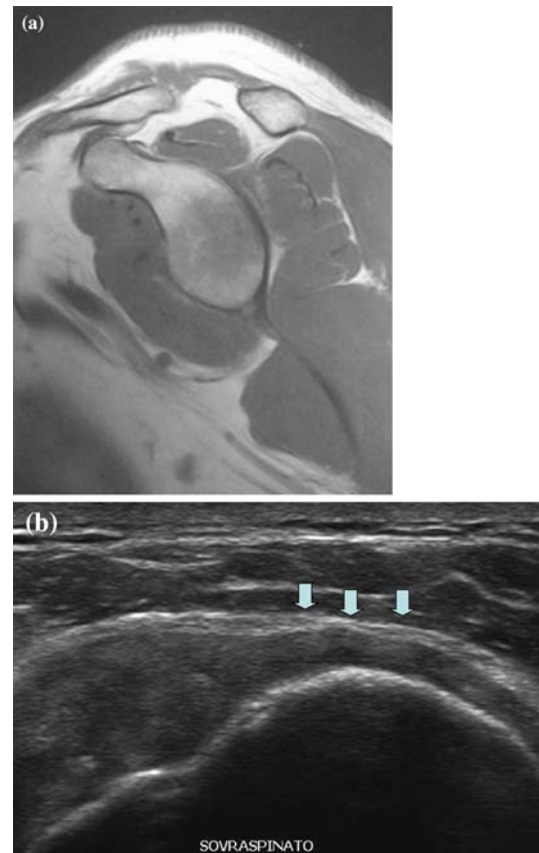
a Pre-operative MRI showing a grade I degenerative fatty infiltration of supraspinatus tendon. b Postoperative ultrasound images of the same patient at follow-up shows a healed tendon (arrows)
